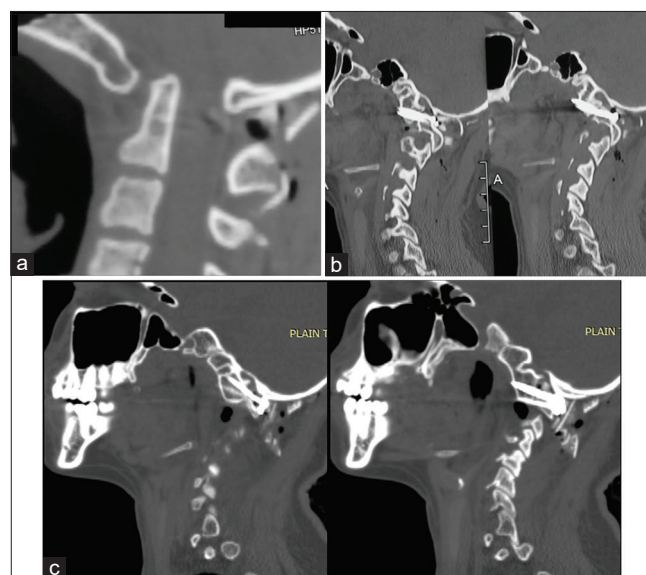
Postoperative images. (a) Postoperative image showing a reduction of basilar invagination and craniocervical junction realignment. (b) Postoperative computed tomography scan of the left side articulation showing the two screws traversing in a transarticular fashion (Magerl technique). The location of the vertebral artery dome inferior to the traverse of the screws can be seen. (c) Computed tomography scan with the cut passing through the right facet articular surface. Both Goel and Magerl techniques were simultaneously used
